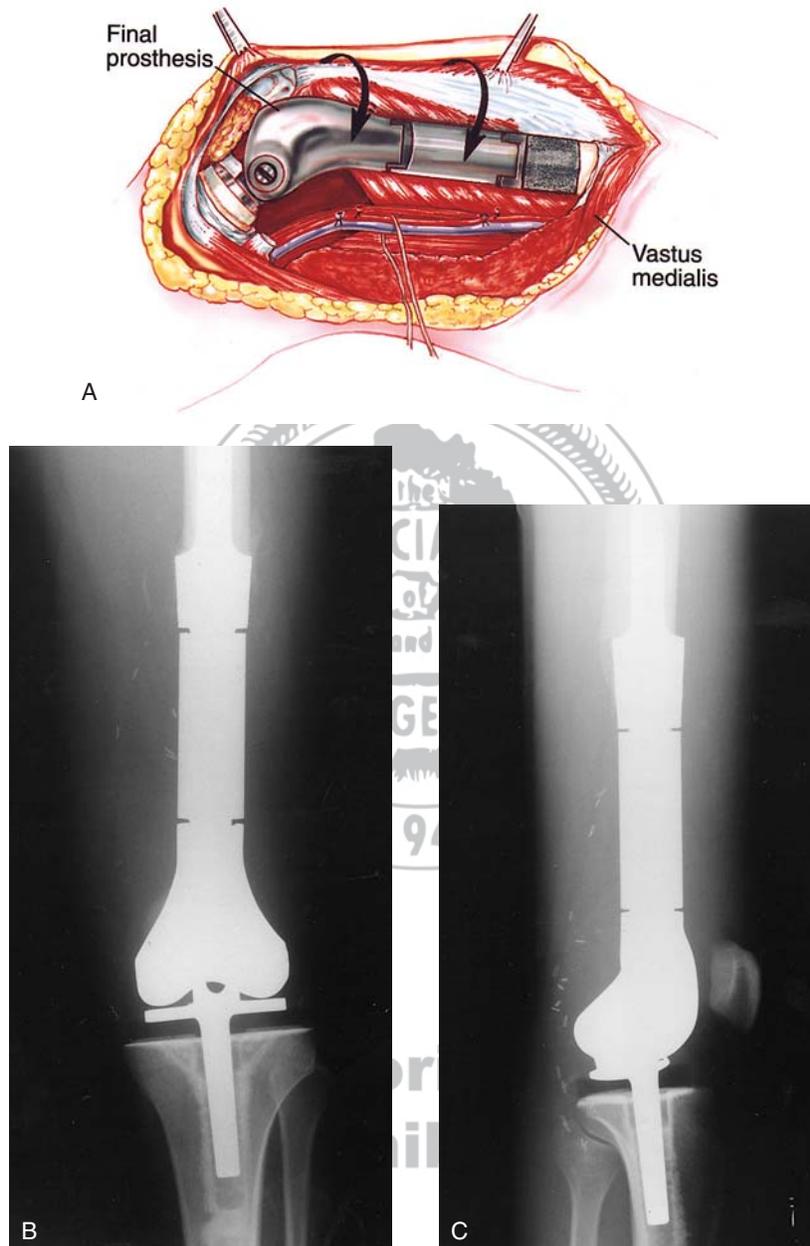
(A) Installation of the definitive modular prosthesis is shown. Reprinted from Malawer M. Chapter 30 “Distal Femoral Resection with Endoprosthetic Reconstruction” In Malawer MM, Sugarbaker PH *Musculoskeletal Cancer Surgery: Treatment of Sarcomas and Allied Diseases*. Kluwer Academic Publishers Dordrecht 2001. Page 480 (B) Anteroposterior Reprinted from Malawer M. Chapter 30 “Distal Femoral Resection with Endoprosthetic Reconstruction” In Malawer MM, Sugarbaker PH *Musculoskeletal Cancer Surgery: Treatment of Sarcomas and Allied Diseases*. Kluwer Academic Publishers Dordrecht 2001. Page 467 and (C) lateral plain radiographs obtained at the 9-year followup show a modular endoprosthetic reconstruction of the distal femur after resection of an osteosarcoma (Howmedica, Rutherford, NJ).
